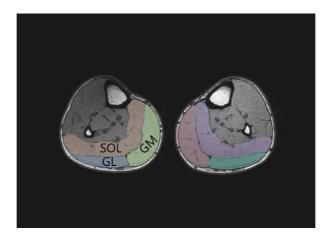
Axial MR images of gastrocnemius lateral head (GL), gastrocnemius medial head (GM), soleus (SOL).
